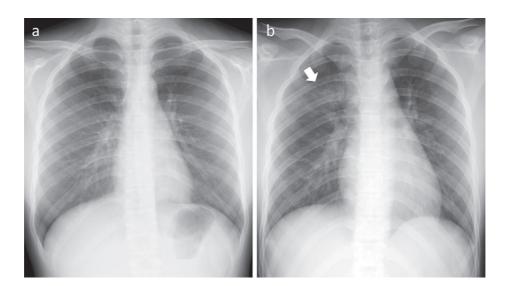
(a) Preoperative and (b) 24 hours after tracheal extubation chest radiographs. Showing (b) expansion of the cardiothoracic ratio and pulmonary opacity over the right upper lobe (white arrow).
